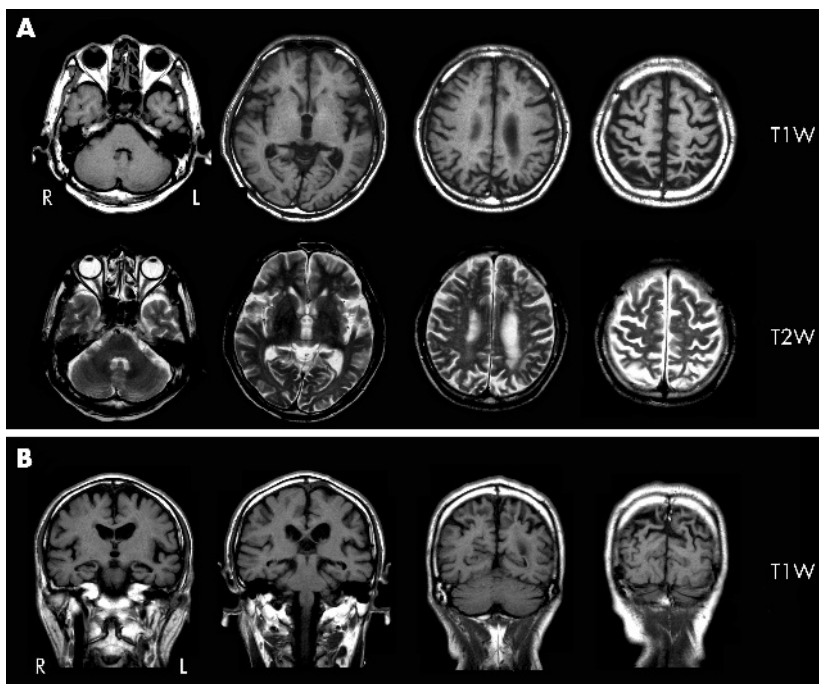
MRI imaging of patient. T1 and T2 images show bilateral parieto-occipital, occipital, and mild left temporal atrophy in horizontal (A) and coronal (B) sections.
